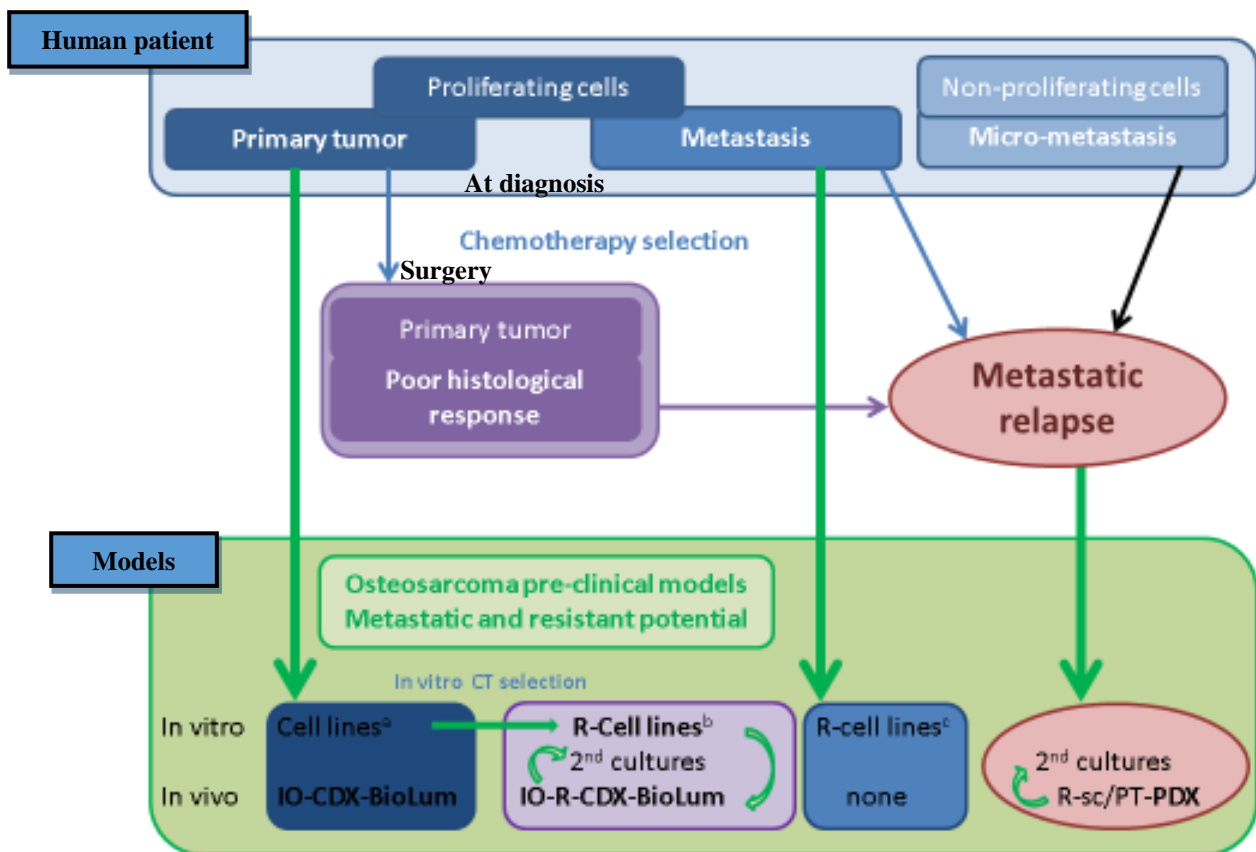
Tumor development in human patients and the different *in vitro* and *in vivo* models developed in this thesis. At diagnosis, patients with osteosarcoma present as primary tumors with or without visible metastases or undetectable micro-metastasis. Relapses, usually metastatic, arise from either primary tumor or metastatic tumor, after chemotherapy pressure selection or not (non-proliferating micrometastases not sensitive to chemotherapy). *In vitro* and *in vivo* models have been derived from these different human disease states. Established *in vitro* cell lines were usually derived from sensitive primary tumors (a), more rarely from resistant metastatic samples (e.g. IOR/OS18 derived from metastases with intrinsic resistance) (c), or were rendered resistant by *in vitro* exposure to chemotherapy to a single agent Methotrexate or doxorubicin (b). CDX models were derived from these established cell lines. PDX models were directly derived from human samples at relapse. CT=chemotherapy.
